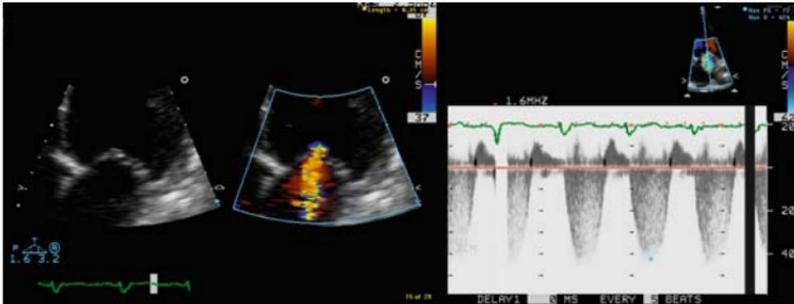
Use of PISA method in a patient with mitral regurgitation. a): The aliasing (Nyquist) limit for velocities away from the transducer is lowered to expand the convergence area and the mitral valve and the proximal regurgitant jet are zoomed-in using the apical 4-chamber view. The radius of the convergence hemisphere is measured (green dots) from the leaflets level to the aliasing boundary (bright yellow-blue interface). b): The peak velocity of the regurgitant jet is obtained with CW Doppler. (See text for calculations) PISA: proximal isovelocity surface area
